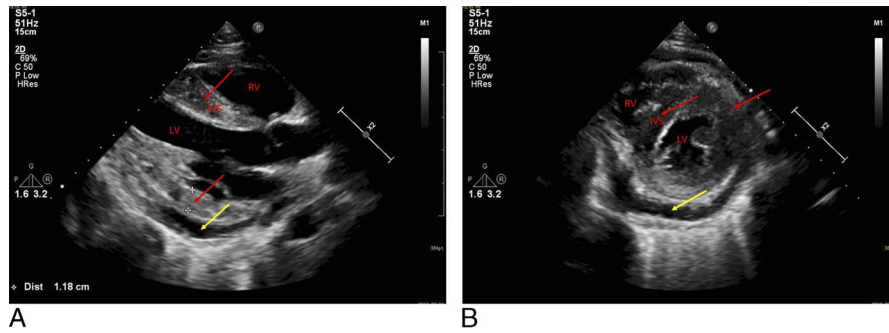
Echocardiography. Parasternal long-axis view (A) and short-axis view (B) of papillary muscle of left ventricle. Thickened interventricular septum and posterior wall of left ventricle (red arrows) and moderate to large amount of pericardial effusion (yellow arrows).
